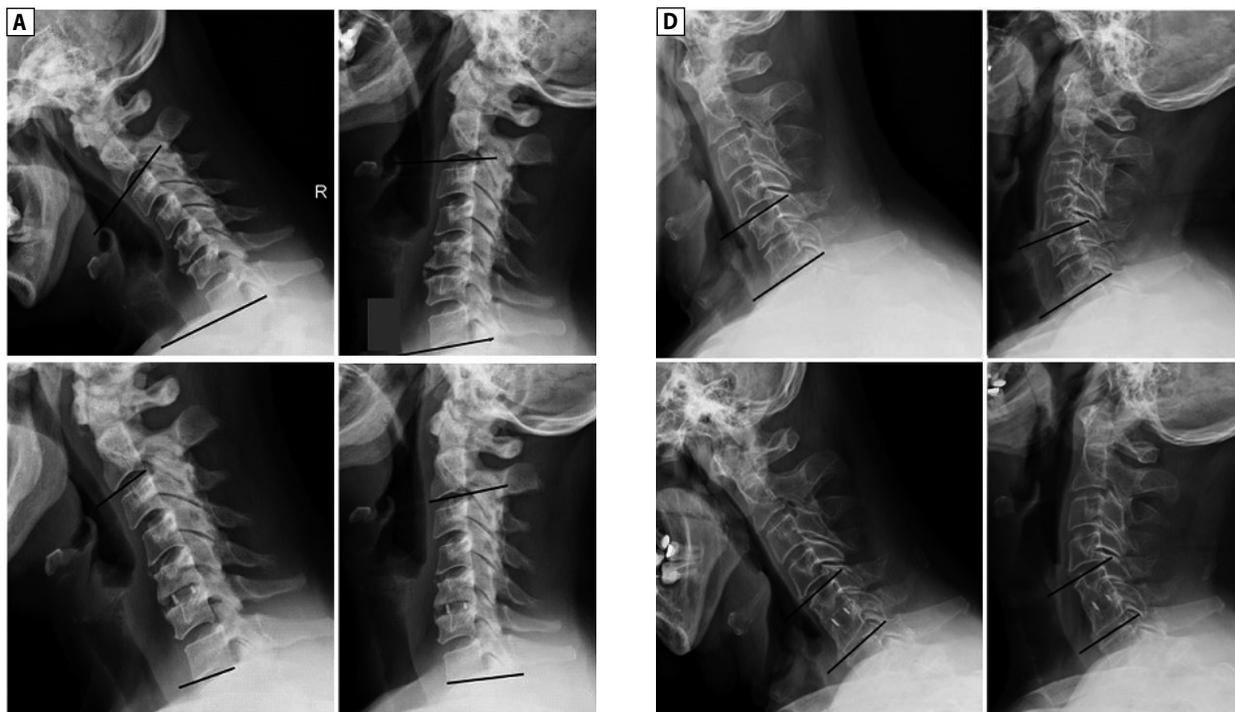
Measurement of spinal mobility: (A) ROM for C2–C7, (B) ROM for the segment located above the operated one, (C) ROM for the segment located below the operated one, (D) ROM for the operated segment. All ROM values determined based on Cobb angle measurement, on archival radiographs from the Department of Neurosurgery, Medical University of Białystok
